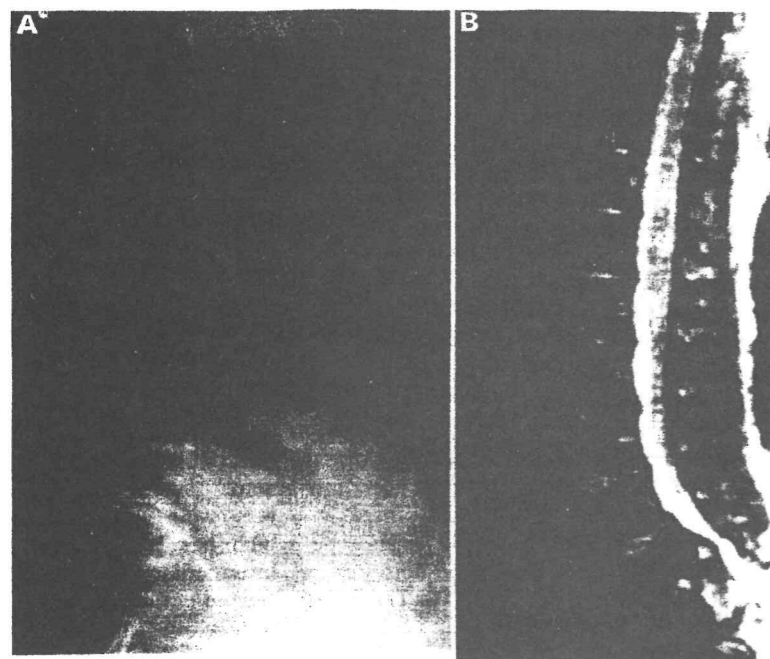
Radiograph of the lumbar-sacral spine in a patient with MPS IS showing the typical lumbar-sacral spondylolisthesis. (B) Magnetic resonance image of the same patient showing narrowing and compression of the spinal canal at the level of the spondylolisthesis.
